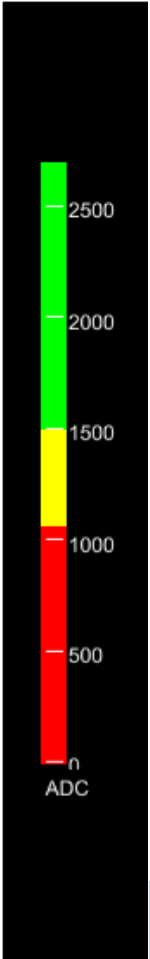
Single-site disease progression after 9 months of response to therapy in the right hemipelvis visualized by diffusion-weighted whole-body MRI. Top, fusion of the T1-weighted imaging and diffusion-weighted imaging; bottom, apparent diffusion coefficient (ADC) maps. Areas of high signal on diffusion-weighted imaging and low ADC values indicate tumor bone marrow infiltration. Left, baseline MRI scan, showing diffuse tumor infiltration in the pelvic bone. The first trial biopsy was taken from the left iliac bone (red circle) and identified a deleterious *BRCA2* mutation with LOH. After 12 weeks of therapy (middle), there was a major response to therapy reported. After 9 months (right), the MRI identified a focal area of tumor relapse in the right iliac bone, which was biopsied (red arrow). Next-generation sequencing of this biopsy confirmed a *de novo* mutation in *BRCA2* restoring the open reading frame.
